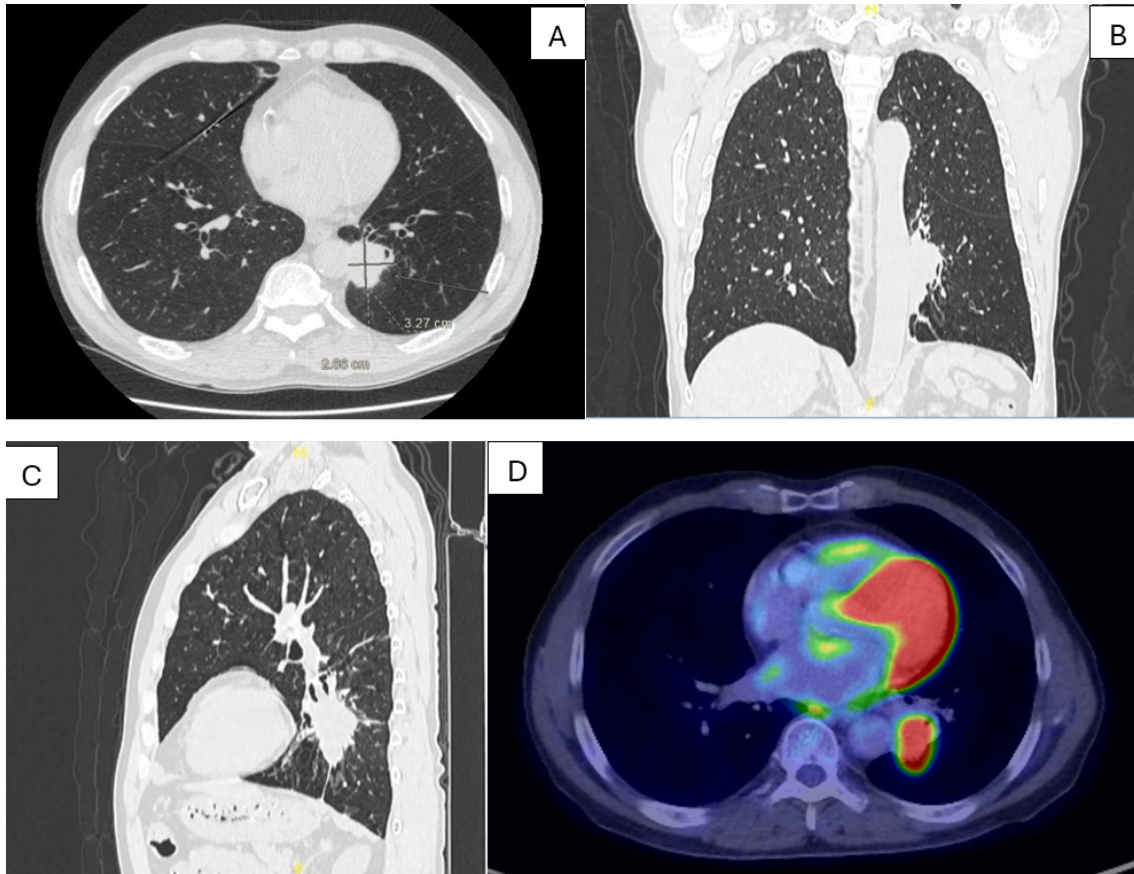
(A–C) Non-contrast chest CT scan (axial, coronal, sagittal views) showing a 3.2 cm solid, well-defined pulmonary mass in segment S10 of the left lower lobe, abutting the mediastinal pleura and adjacent to the descending thoracic aorta. The fat plane between the mass and the aorta is preserved. (D) PET/CT scan demonstrating intense FDG uptake in the left lower lobe mass with a SUVmax of 10.6.
